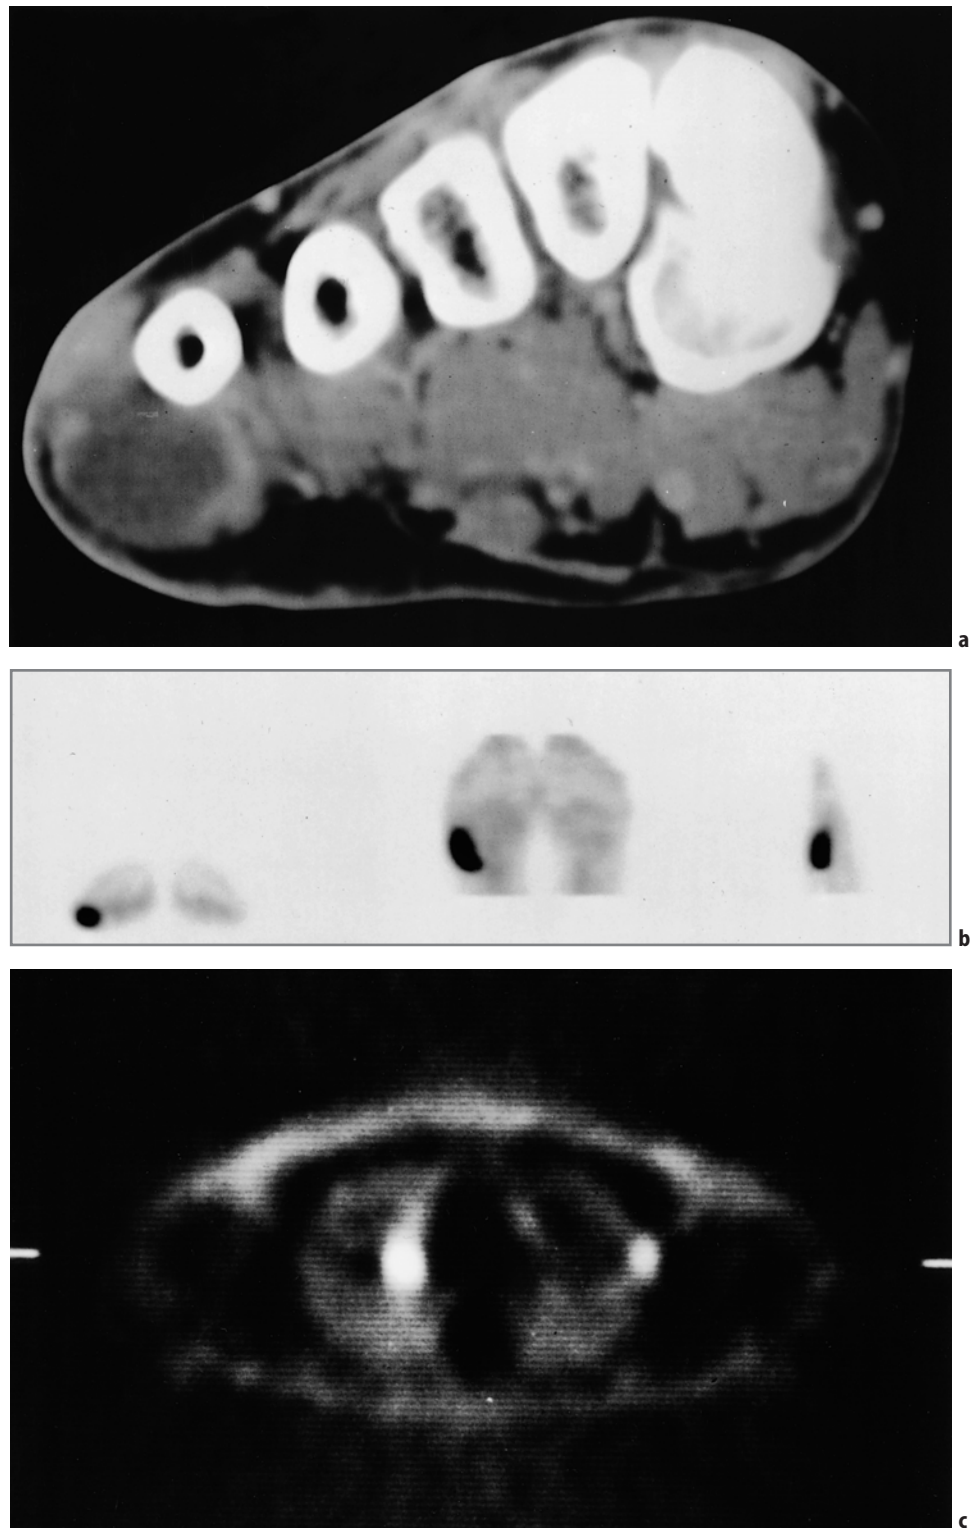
Rhabdomyosarcoma. (a) CT of the right foot of an 18-year-old girl following chemotherapy shows abnormal residual soft tissue mass below the right fifth metatarsal. (b) Depicted *left to right* are transverse, coronal, and sagittal images. (c) Nonattenuation-corrected images of the chest show metastases in the medial right lung and lateral left lung. (Reprinted with permission from Shulkin BL. PET applications in pediatrics. *Q J Nucl Med* 1997;41:281–291.)
